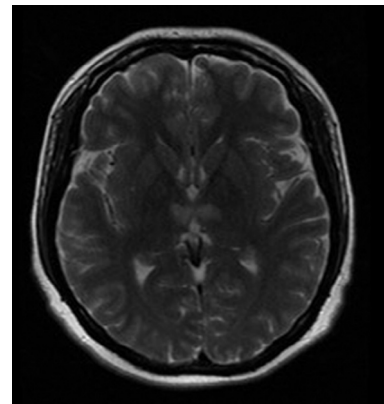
Brain MRI, T2 images showing a bilateral, symmetrical restricted diffusion at diffusion-weighted images of the thalamus. Abbreviation: MRI, magnetic resonance imaging.
